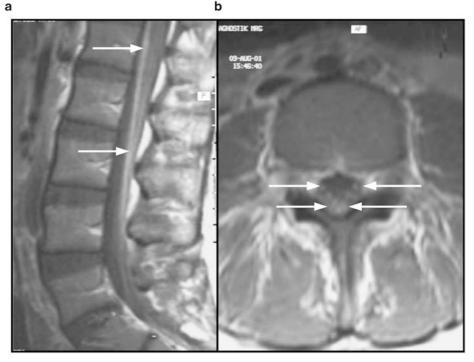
(a) Postcontrast sagittal T1-weighted image showed diffuse contrast enhancement on the distal cord and cauda equina (arrows). (b) Postcontrast axial T1-weighted image from the level of the fourth lumbar vertebra showed thickening and enhancement of the nerve roots (arrows). These findings indicated nonspecific inflammation involving the distal cord and the nerve roots
